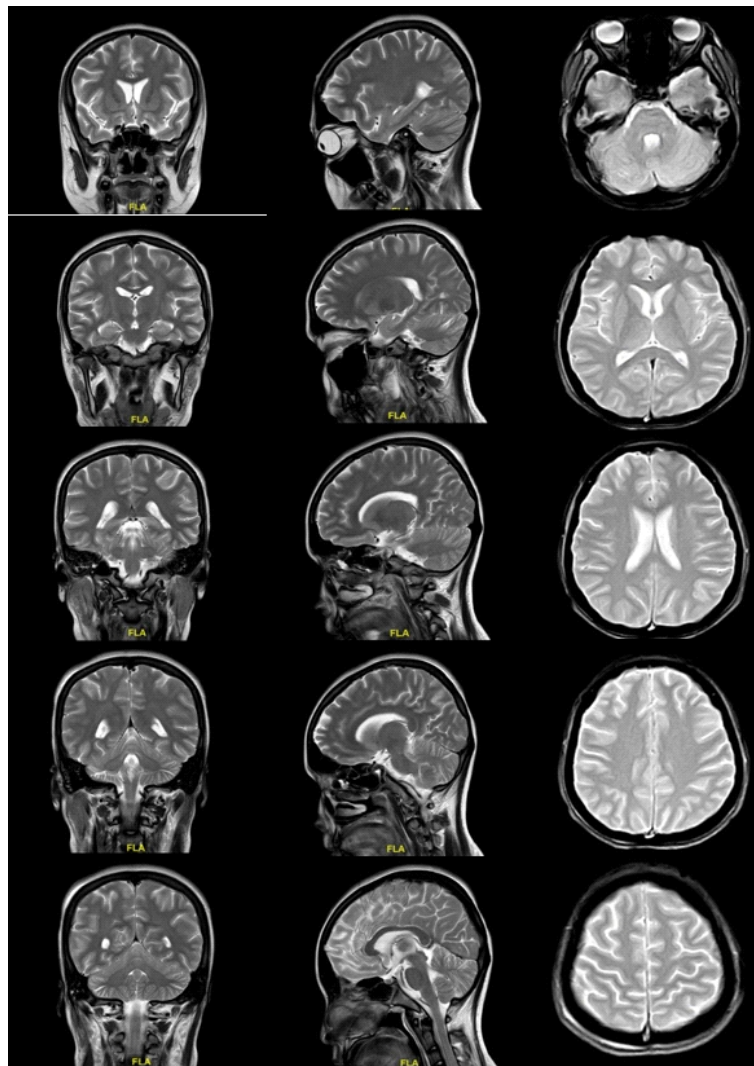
Magnetic Resonance Imaging (MRI) head/brain. Non-contrast MRI does not appear abnormality.
